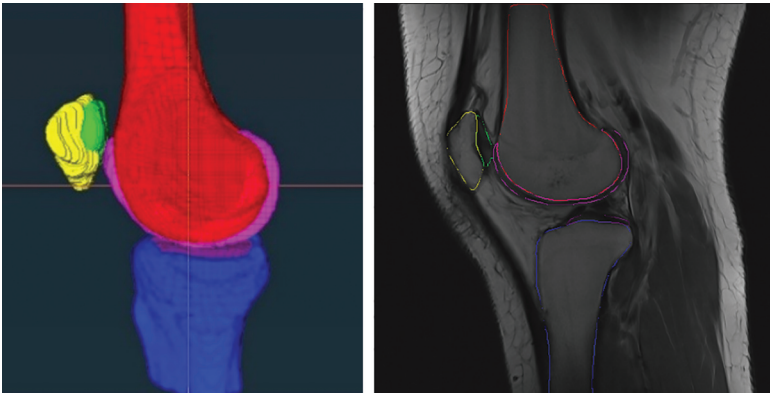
Segmentation of bone and cartilage geometries from patient-specific magnetic resonance imaging scans.
